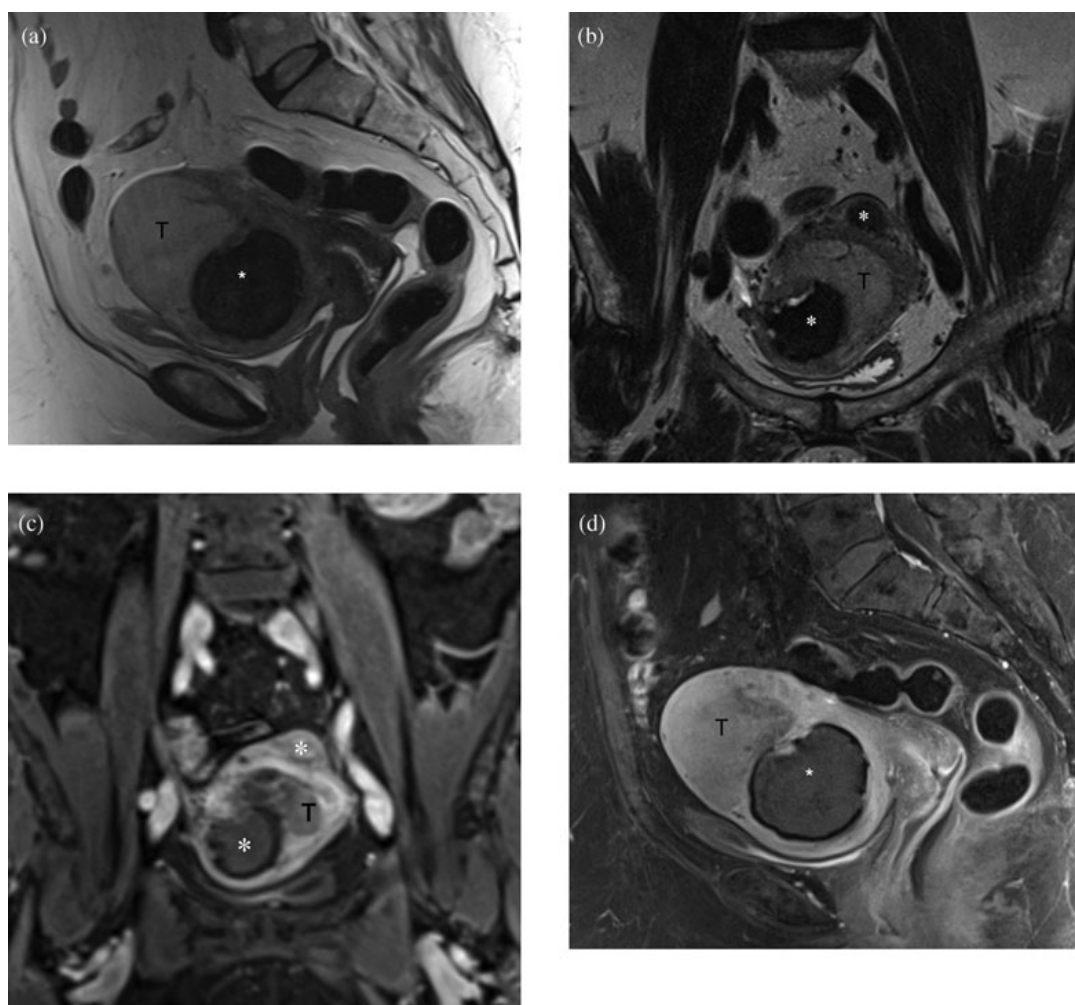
(a) Sagittal turbo spin echo (TSE) T2-weighted image of the uterus in Patient no. 19. The evaluation of tumor invasion by three-dimensional ultrasound was impaired because of a large leiomyoma (*). Magnetic resonance imaging demonstrates endometrial tumor (T) invading more than 50% of the myometrial thickness. (b) Paracoronaral T2-weighted image (perpendicular to the cavity of uterus). (c) Paracoronaral contrast-enhanced three-dimensional volumetric interpolated breath-hold examination image acquired 60 s after contrast injection. (d) Sagittal contrast-enhanced fat-suppressed TSE T1-weighted image acquired two minutes after contrast injection demonstrates a higher contrast between the tumor and myometrium.
